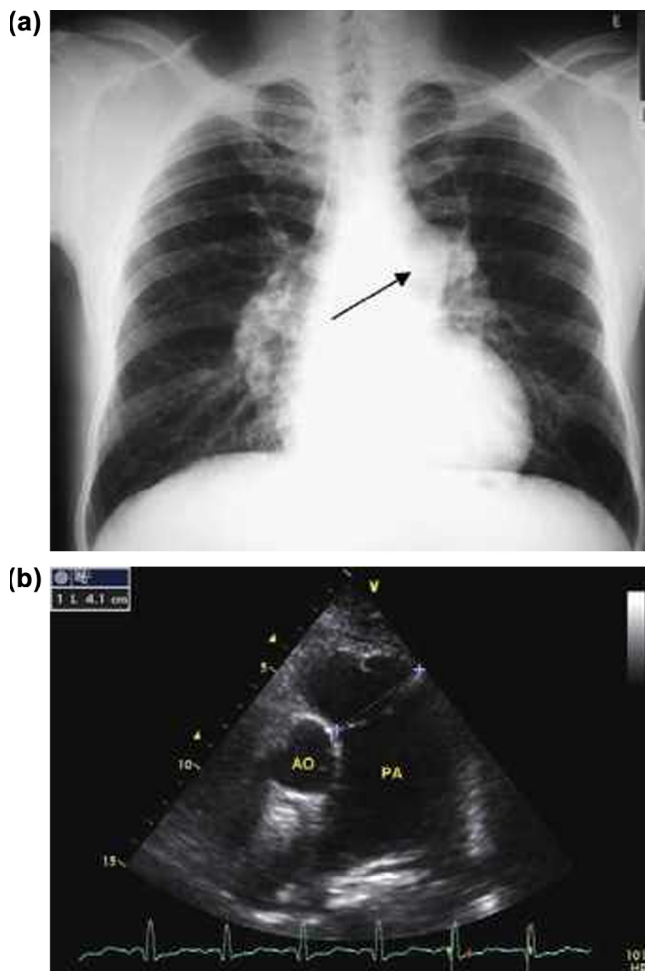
“Bilharzial” cor pulmonale. (a) Chest X-ray showing signs of pulmonary hypertension (prominent fourth arc – arrow). (b) Ecocardiography in a patient with cor pulmonale in schistosomiasis mansoni: PA = trunk of the pulmonary artery; AO = aorta. In normal people the diameter of the aorta is greater than the trunk of the pulmonary artery. The relation here is inverted (note the diameter between the blue crosses) [30] (With permission).
